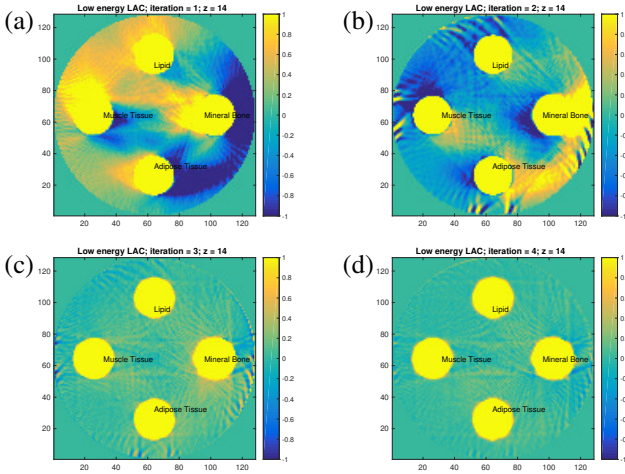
Suppression of cone-beam artifacts in the surrounding air. Colormaps of reconstructed LAC (in  $m^{-1}$ ) for iterations 1 (a), 2 (b), 3 (c) and 4 (d) of regular DIRA-3D reconstruction for the slice  $z = 14$  and photon energy  $E_1 = 50$  keV.
